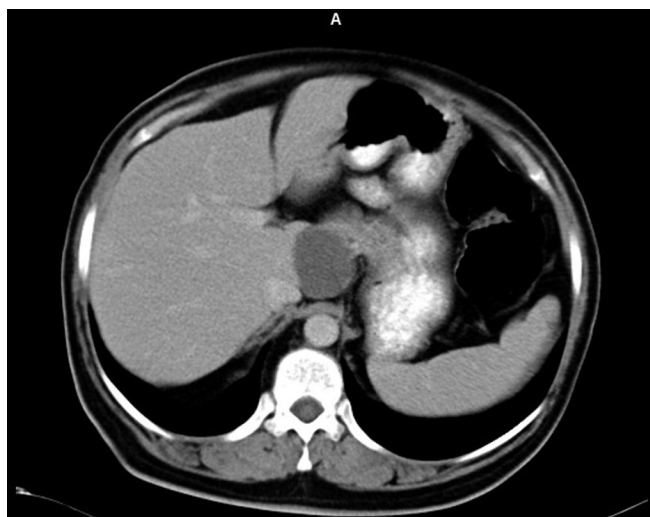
View of the tumor on abdominal CT.
